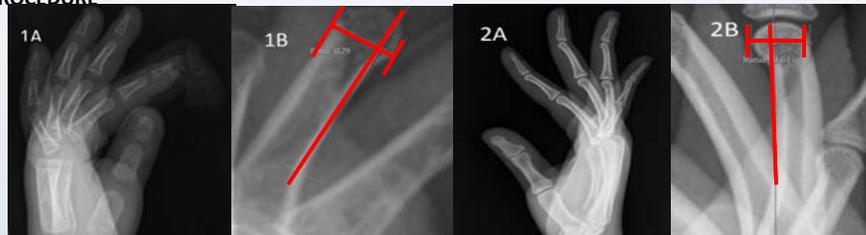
A) Lateral radiograph of the left hand of a 1 year old patient with no noted injury to any digit B) Zoomed in view of the long proximal phalynx. A line was drawn anteriorly along the volar cortex. A perpendicular line was drawn at the phalangeal neck. A ratio of the anterior to posterior aspects of the line was noted. The 0.29 ratio of the lengths denotes that the line is 22% anteriorly or in the anterior 1/3rd of the finger
